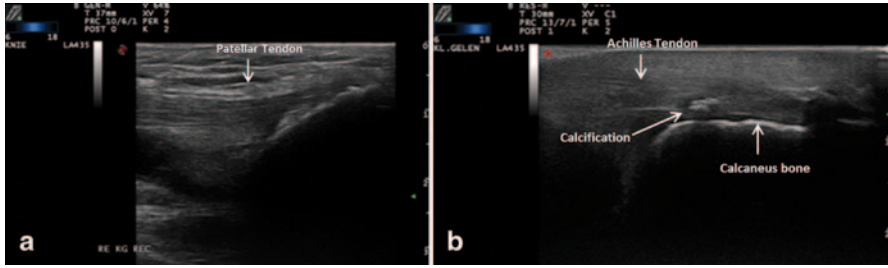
a Sonographic B-mode image showing calcification of the patellar tendon. b Sonographic B-mode image showing calcification of the Achilles tendon
